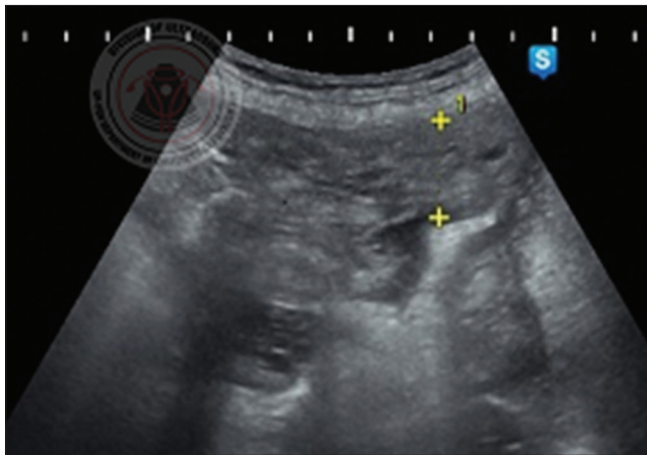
Omental thickening and caking are seen on ultrasound among cases with pseudomyxoma peritonei, significantly more common in peritoneal mucinous carcinomatosis type
